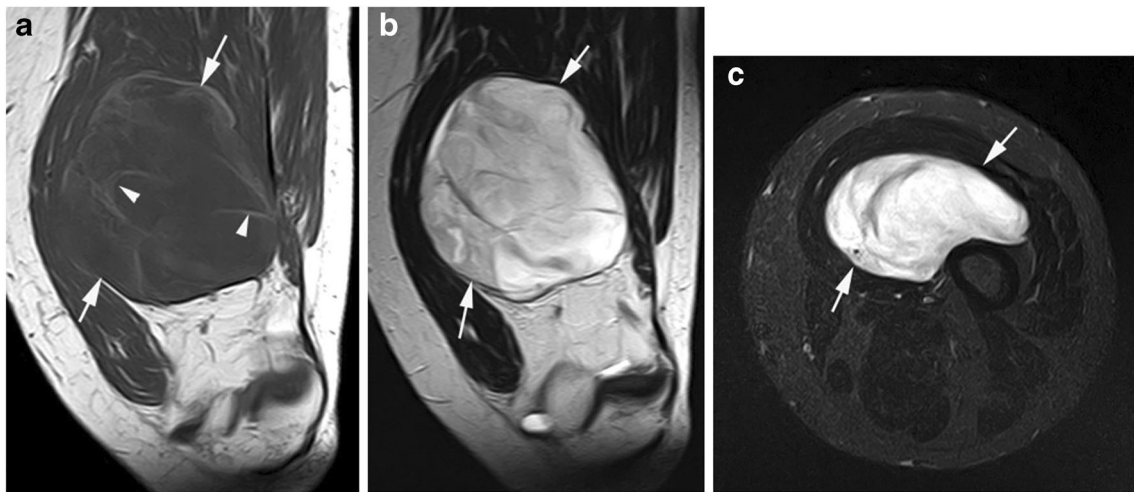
A 47-year-old male presenting with a mass in the anteromedial aspect of the distal left thigh. a Coronal T1W TSE, b coronal T2W FSE, and c axial STIR MR images show a well-defined, lobular mass (arrows) which is isointense to muscle on T1W and hyperintense on T2 and STIR.
